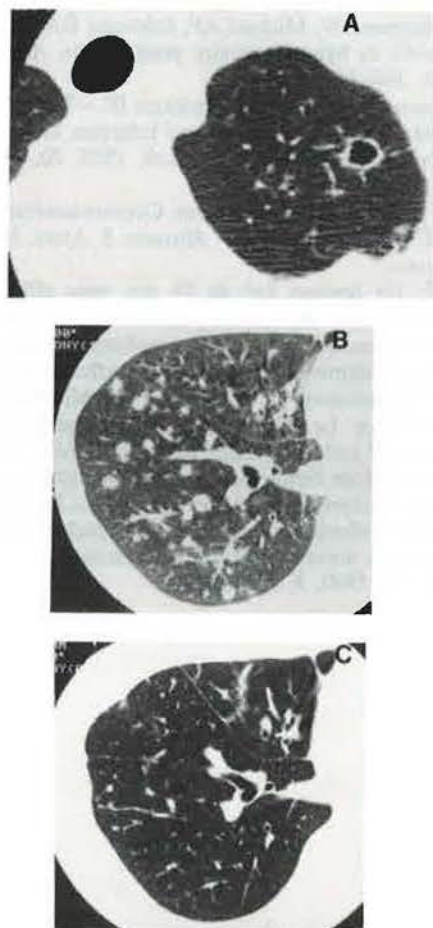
Computed tomographies of the lung revealed a) a cavity in the left upper lobe S¹⁺³ and b) multiple nodules which related to the bronchial tree. c) After treatment, these lesions disappeared.
